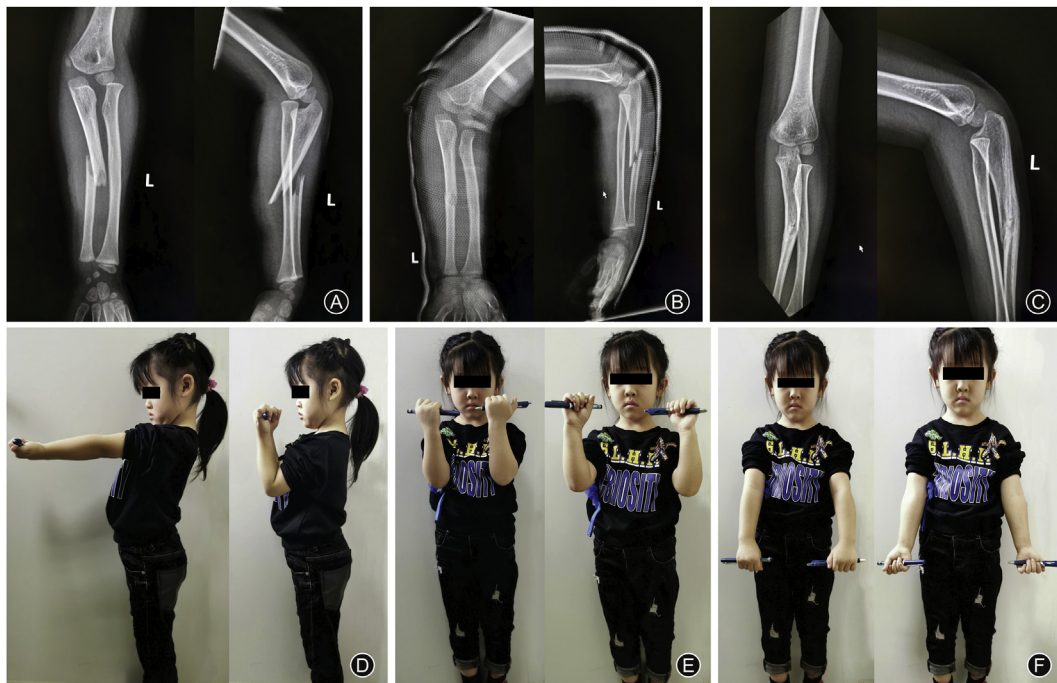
(A–C) Anteroposterior and lateral plain films including the elbow joint. (A) Before manual reduction, the fracture occurred at the left proximal ulna, and the radial head was anterolaterally dislocated. (B) After manual reduction, the dislocated humeroradial joint was partly reduced and the deformity at the fracture site of the proximal ulna had been corrected. (C) The humeroradial joint was stable in any position at 6 months after manual reduction. (D–F) Six-month follow-up images. (D) The elbow range of motion was extension to 0°, flexion to 130°. (E and F): The forearm range of motion was supination to 90°, and forearm pronation to 90°.
